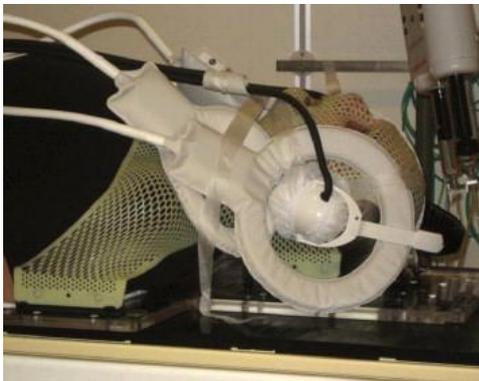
Head coil for MRI, attached to a radiotherapy fixation mask [19]
